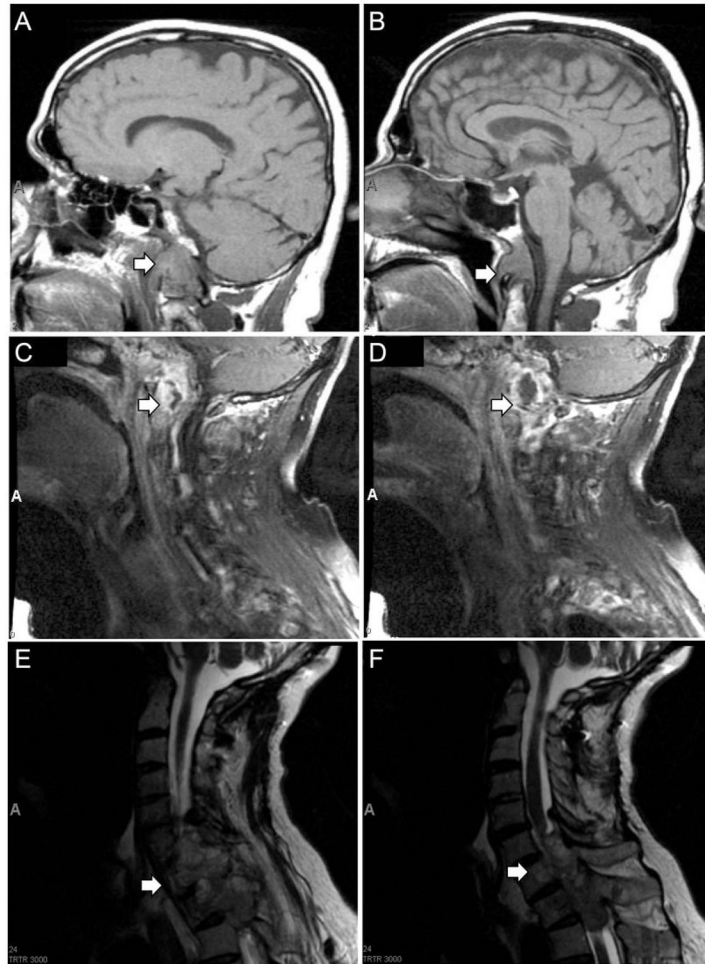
Magnetic resonance imaging of primary clival chordoma and recurrent tumor involving the cervical and thoracic spine
